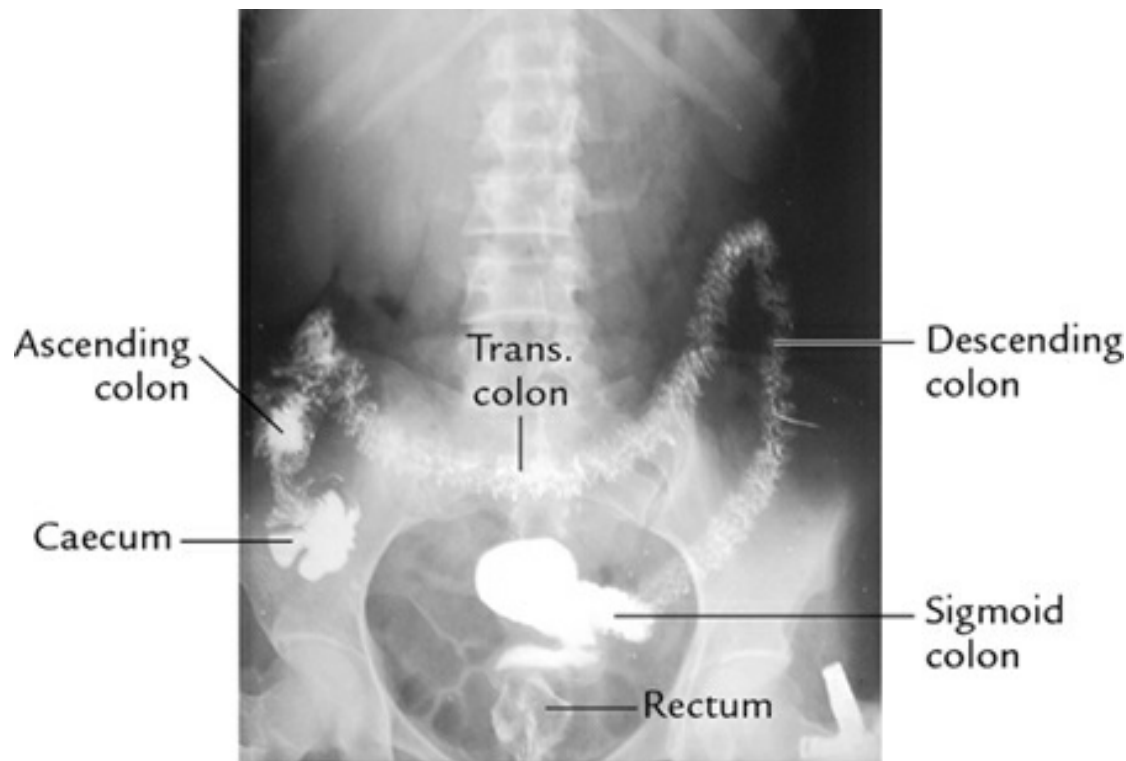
■ Barium meal X-ray. (Source: Fig. 5.25, Page 250, *Last's Anatomy: Regional and Applied*, 12th ed, Chummy S
